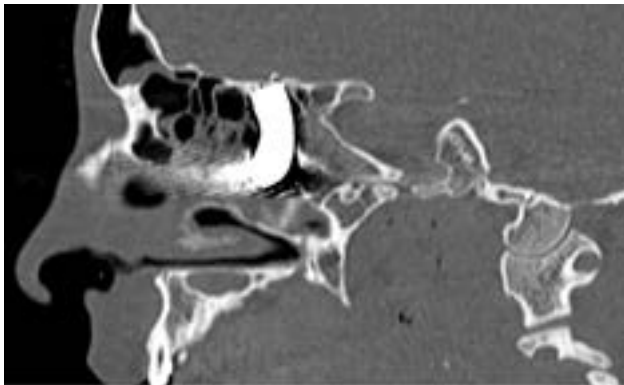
A metallic foreign body is seen in the sagittal section of computed tomography scan, breaking through the ethmoid bone and penetrating into the anterior wall of the sphenoid sinus.
